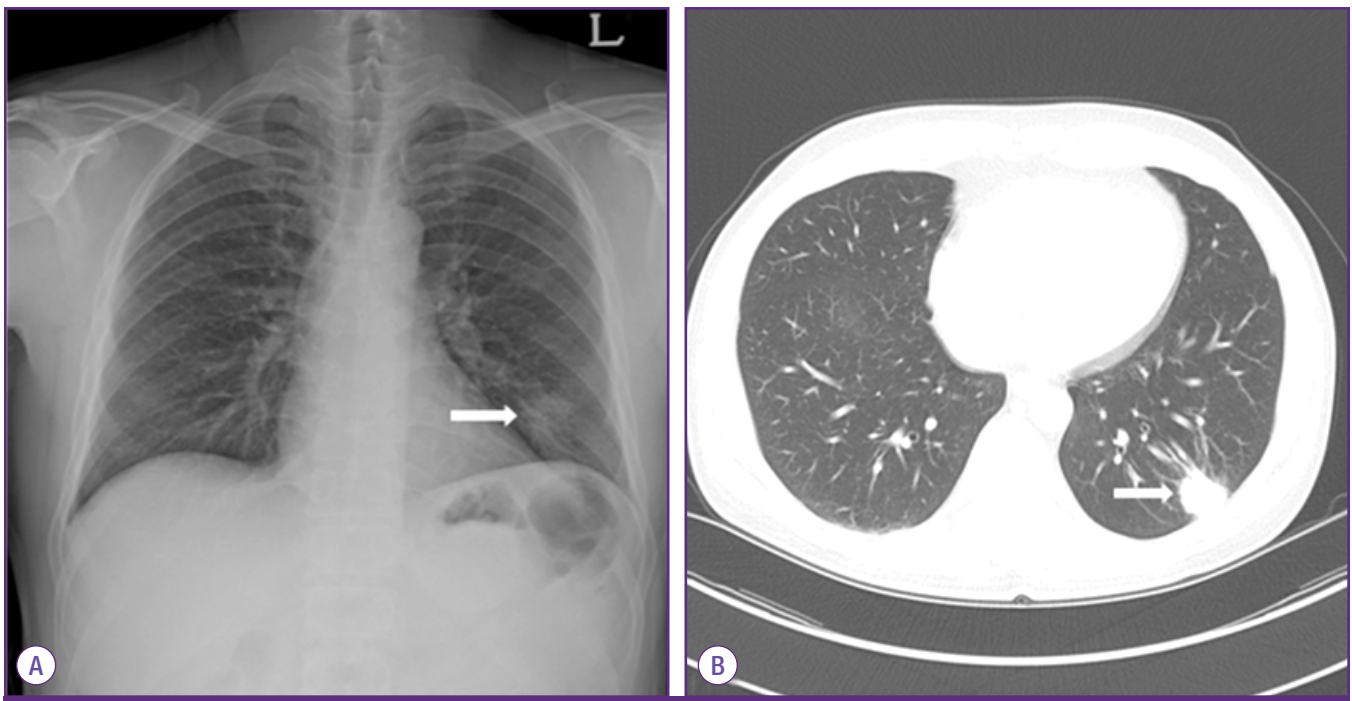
Initial chest roentgenogram shows mass-like opacity (arrow) in the left lower lobe (A). Initial chest CT shows a 2.2 cm mass (arrow) in the left lower lobe with a spiculated border and peripheral subsegmental atelectasis (B).
